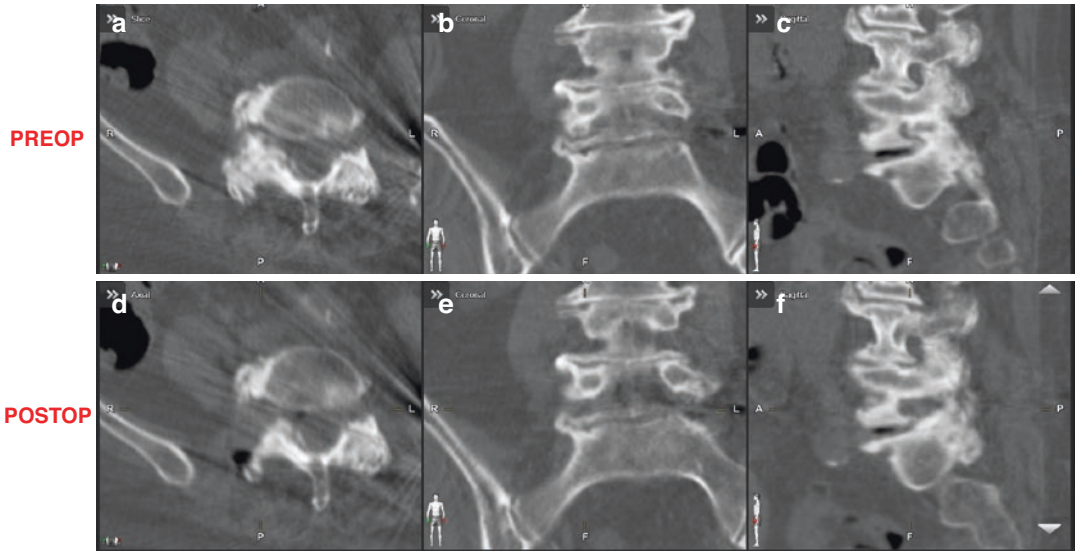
Right L5/S1 far lateral discectomy and decompression. (a, b, c) Preoperative CT Images; (d, e, f) Postoperative CT images
